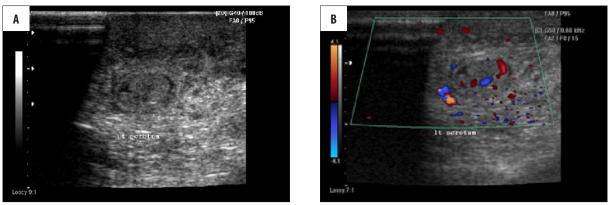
(A) Sonogram showing enlarged testes with increased echo texture, marked thickening of the scrotal skin and minimal fluid collection in the sac. Left epididymis is enlarged and shows increased echotexture. (B) Color Doppler of the left scrotum shows increased vascularity of the testis.
